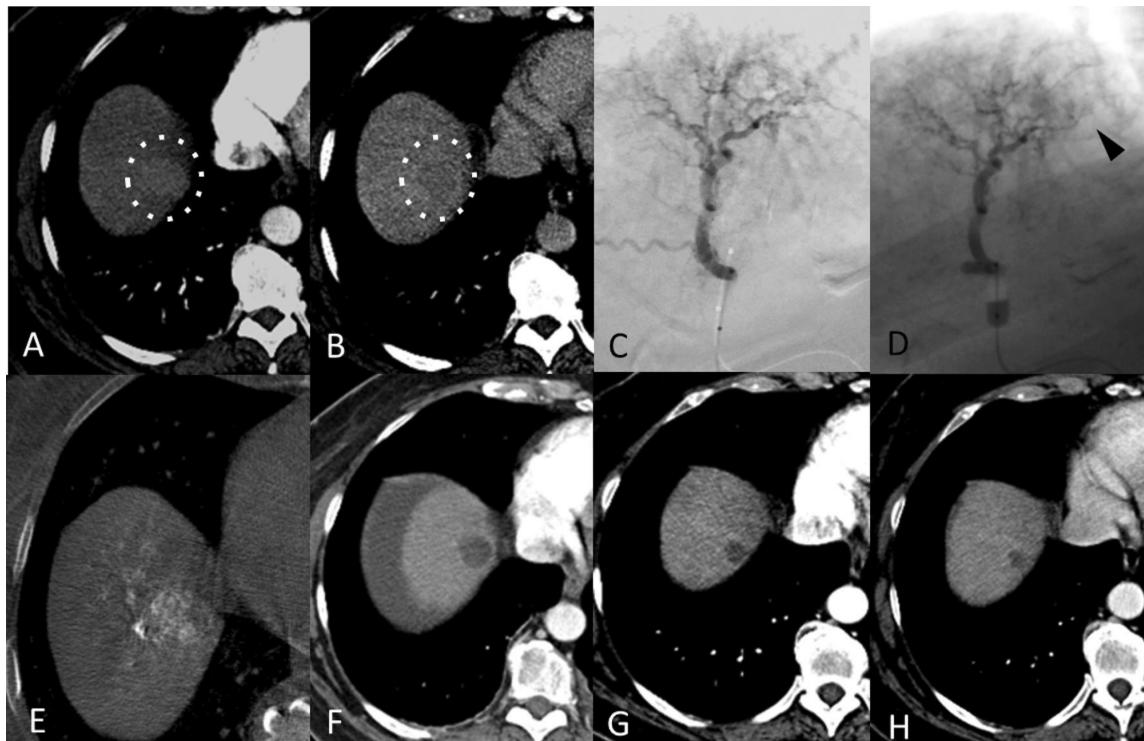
A 64-year-old woman, with alcoholic and HCV cirrhosis complicated by a slightly hypervascular HCC in the arterial phase (A, dotted circle) in segment VIII, with late washout (25 mm) (B, dotted circle), undergoing a balloonoccluded TACE procedure. The angiography performed with a deflated balloon confirmed the poor hypervascularity of the nodule (C) which improved after balloon inflation (D, arrow head). The unenhanced cone beam CT performed at the end of the bTACE showed the good deposition of the particles within the nodule (E). Onemonth post-procedure CT arterial phase follow-up showed a complete response (F) sustained at 12 months (G) and at the last follow-up available, carried out at 24 months (H). Adapted from Lucatelli
